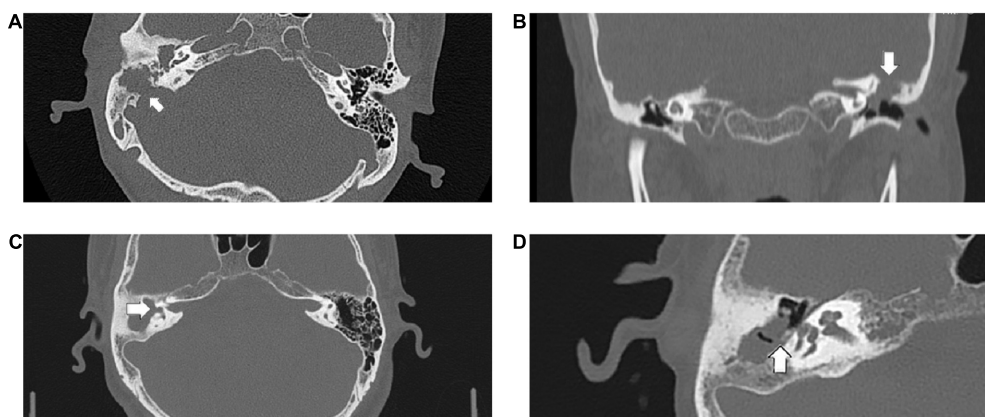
The following CT scan findings were recorded as score 2: (A) the sigmoid sinus bone plate eroded (arrowed), (B) coronal section of the left epitympanum demonstrating a tegmen tympani defect (arrowed), (C) a large defect of the lateral semicircular canal (arrowed), (D) the pyramid segment of facial canal eroded (arrowed).
